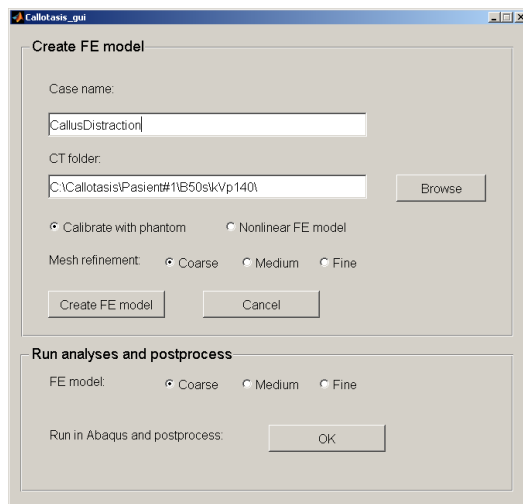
The main GUI of the program. The users enter the path of the CT images and the desired mesh refinement.
